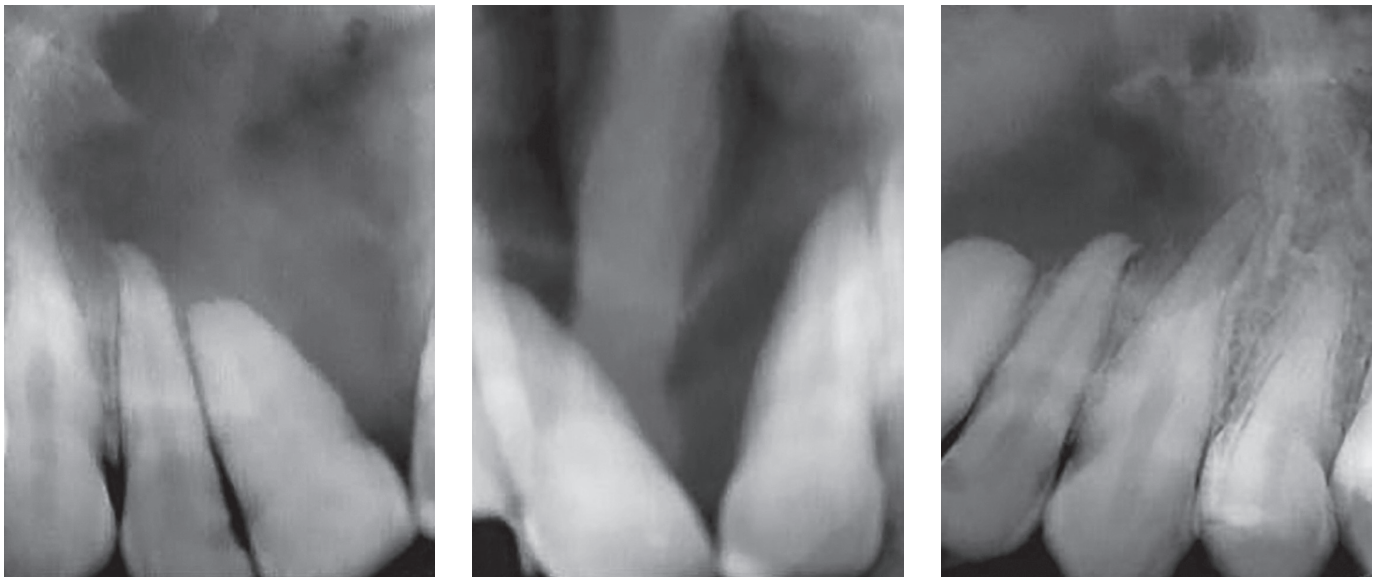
Radiographic images of the region extending from tooth #13 to #23.
